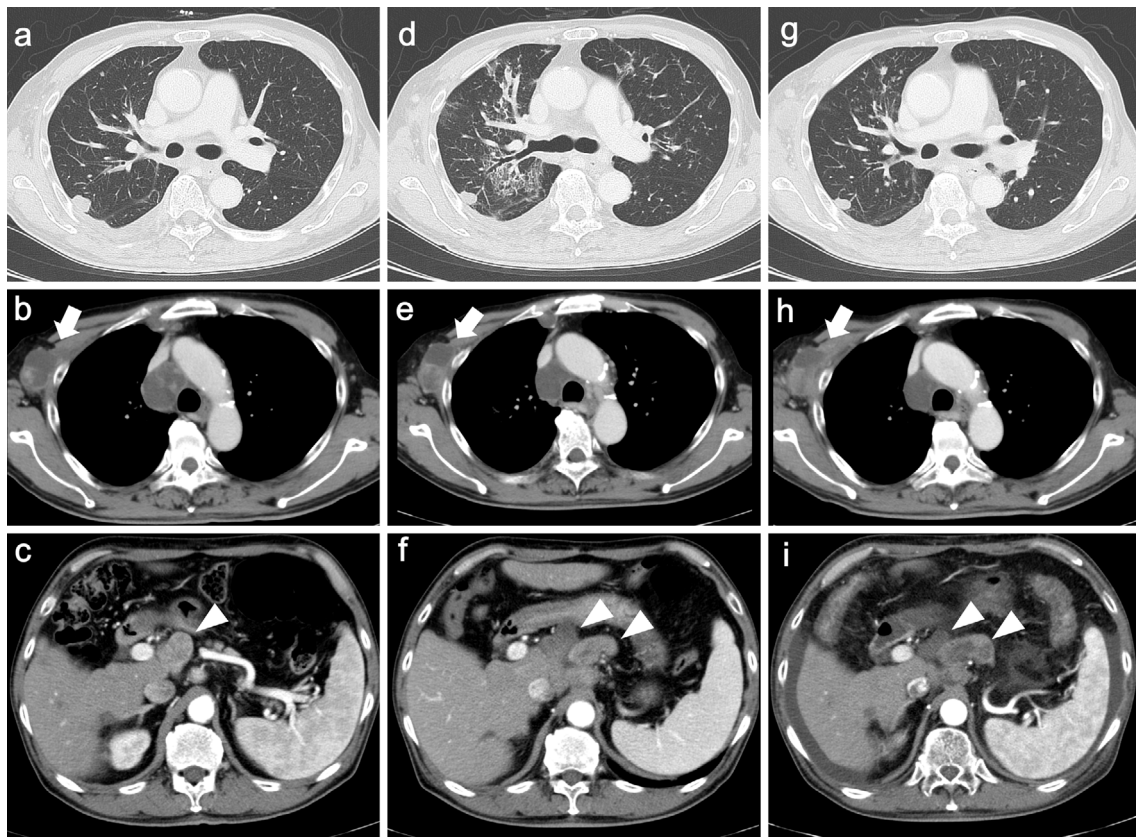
Findings of contrast enhanced computed tomography of mediastinal, axillary (white arrow), and peritoneal (white arrowhead) lymph nodes and lung metastases during sorafenib and regorafenib rechallenge treatment. (a, b, c) After resection of the peritoneal dissemination, the lung metastases had progressed. Mediastinal, axillary, and peritoneal lymph node metastases occurred. The mediastinal lymph node had an avascular area inside the lesion, which was thought to be necrotic due to the previous therapy. (d, e, f) One month after starting sorafenib rechallenge, the mediastinal and axillary lymph nodes and lung metastases had shrunk. An avascular area was detected in the peritoneal lymph node, indicating necrosis. (g, h, i) Two months after starting regorafenib rechallenge, the mediastinal and peritoneal lymph nodes had shrunk slightly, while the axillary lymph nodes showed no change.
